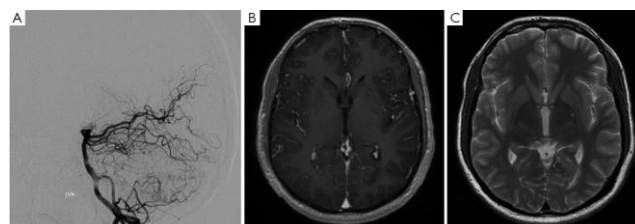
Pre-GKR imaging of left occipital AVM; A) DSA; B) MRI T1 weighted image with contrast; C) MRI T2 weighted image without contrast (top); One-year follow up post-GKR; A) DSA; B) MRI T1 weighted image with contrast; C) MRI T2 weighted imaging without contrast. Showing resolution of left occipital AVM (bottom)
